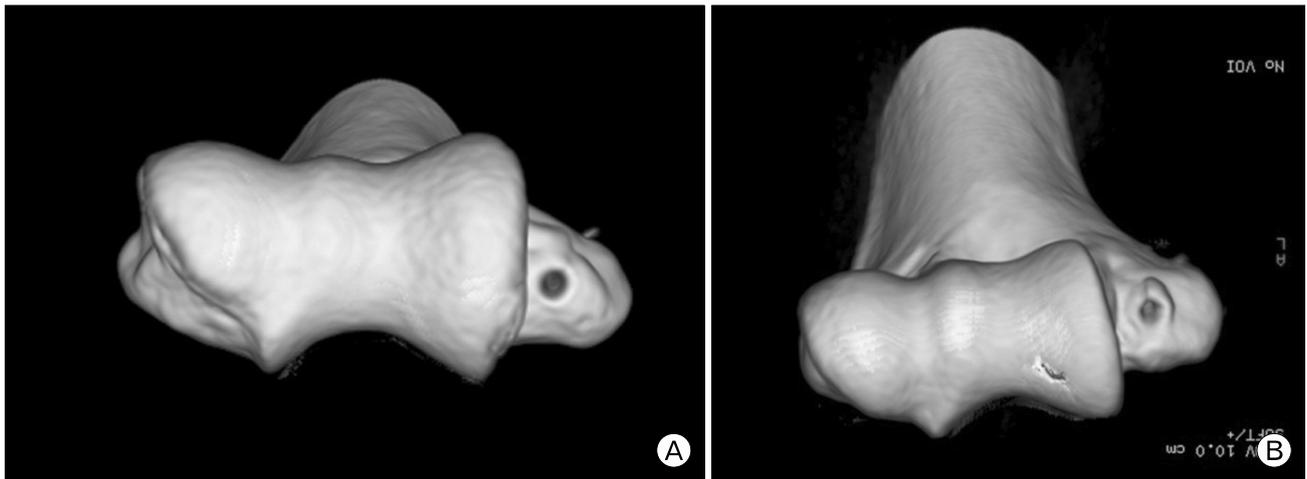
Images of three dimensional reconstructed computed tomography showing the starting point of the humeral tunnel: (A) inferior point, (B) anteroinferior point.
